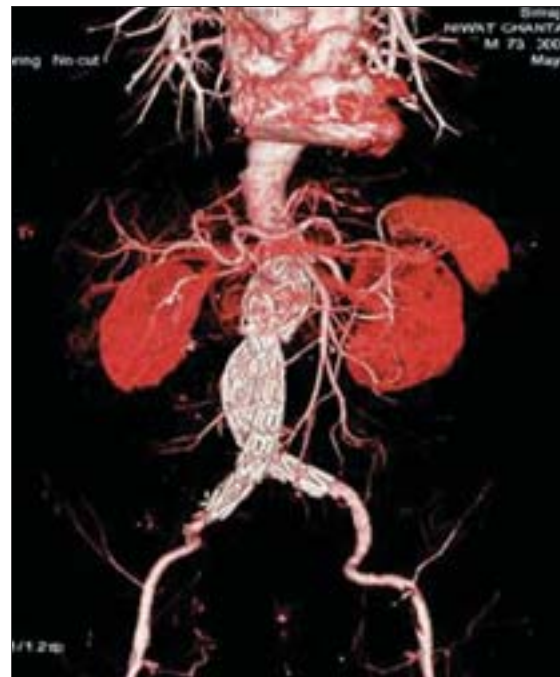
Post-operative CTA with 3-D reconstruction in coronal plane showed proper position of the aortic stent graft just beneath the origin of bilateral renal arteries. Note the cross-shape(x) of both iliac limbs indicating marked tortuosity of the vessels (making very difficult for the equipment delivery)
